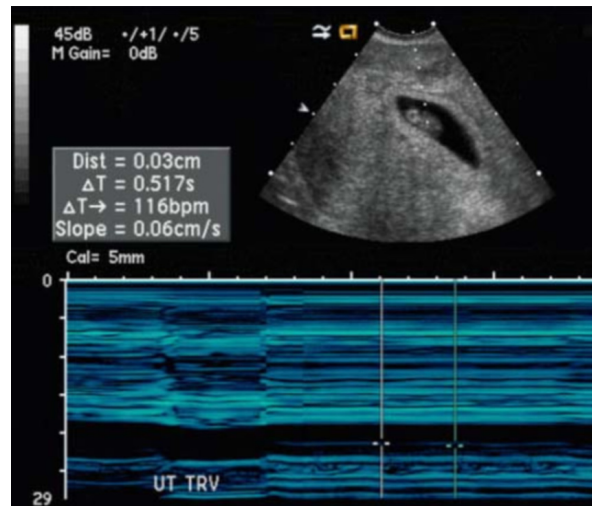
Transvaginal ultrasound documenting cardiac activity (116 BPM) in the intrauterine gestation following selective removal of the ectopic gestation.
